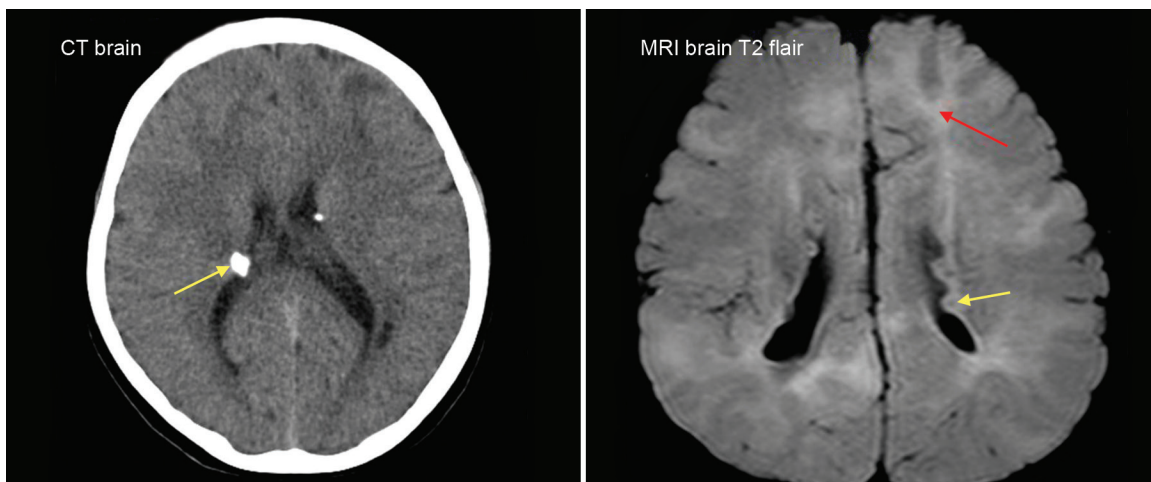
Plain CT brain showing calcified subependymal calcifications (arrow) and MRI brain T2 FLAIR axial image showing subependymal nodules (yellow arrow) seen as projections into the lateral ventricles and high signal intensities involving the cortex which represent cortical tubers (red arrow)
